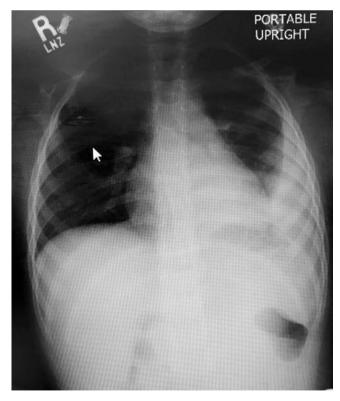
Chest radiograph of a 2-year-old child with left pleural effusion
